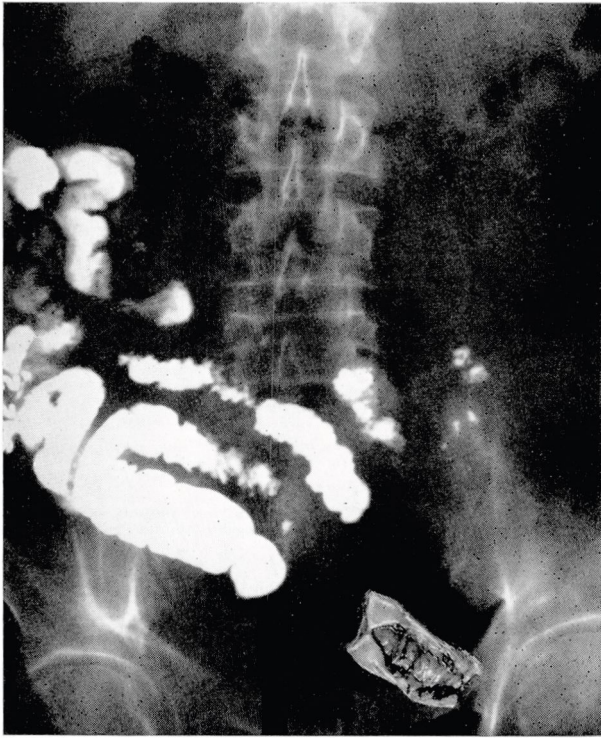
Abdominal roentgenogram of a 63-year-old man who had abdominal cramps for three weeks and vomited fecal type of material. At operation an ulcer was found corresponding to the narrowed small segment of small intestine seen in the roentgen studies.
